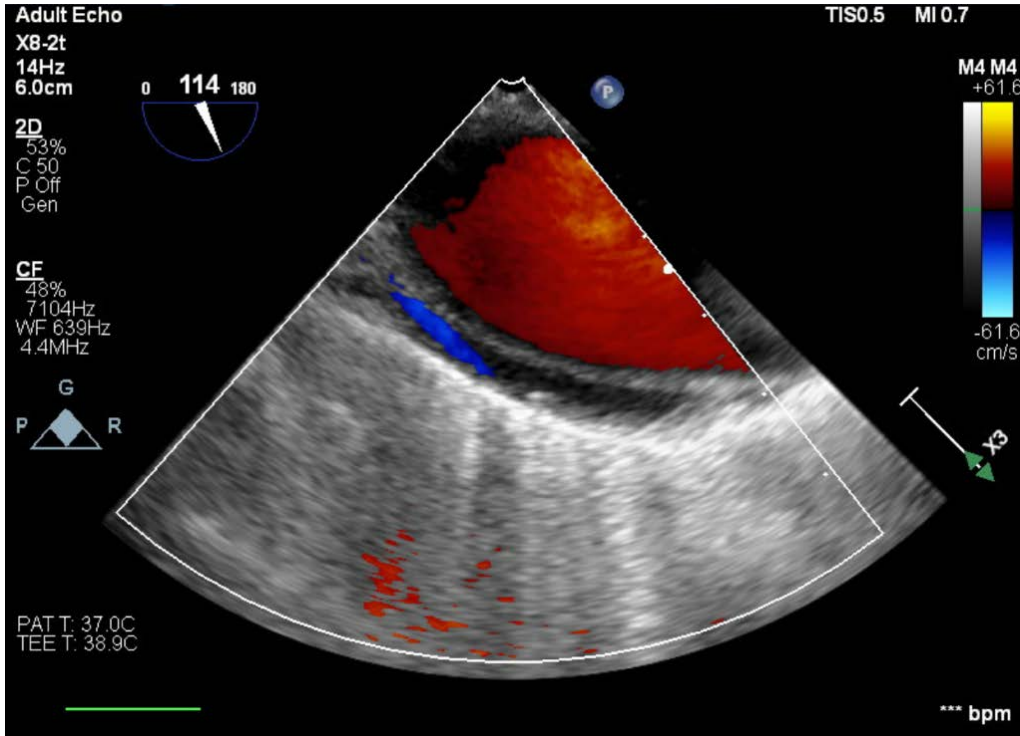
Color Doppler imaging demonstrating bidirectional flow
